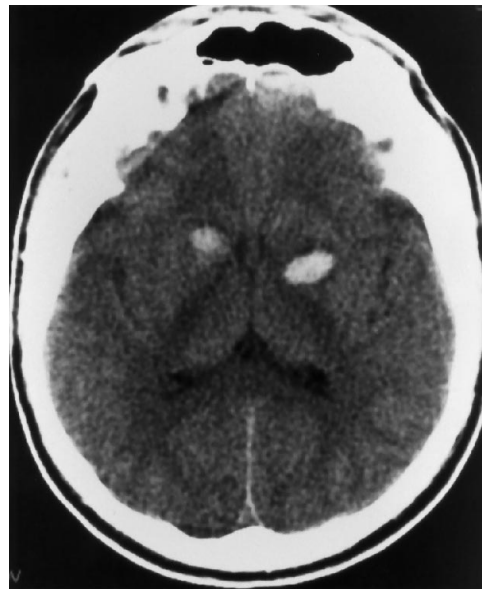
Noncontrast computed tomographic section shows bilateral hemorrhages (*left* greater than *right*) in the lentiform nuclei.
